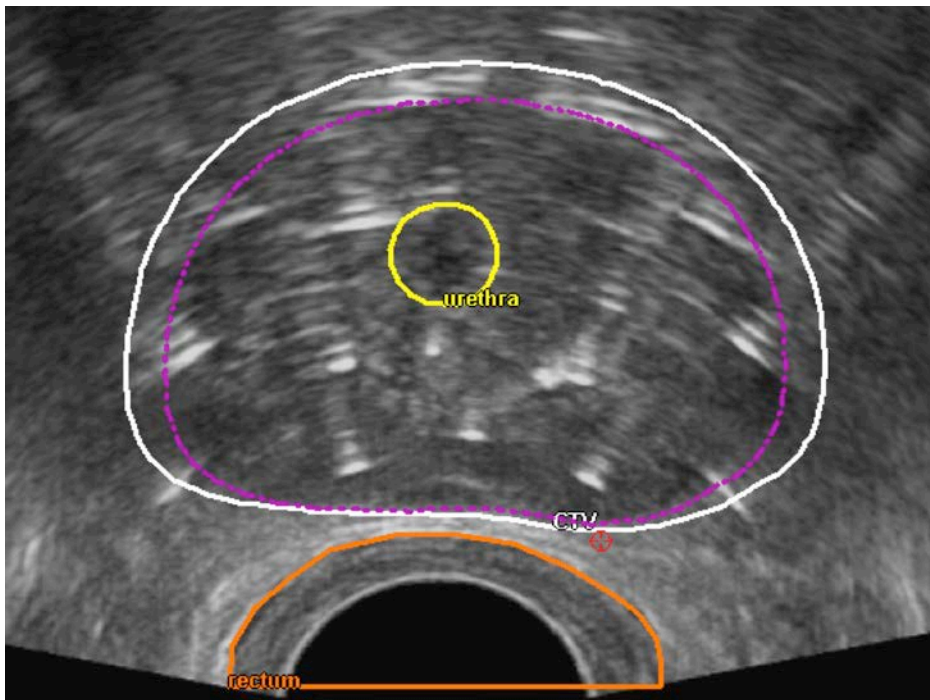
Transverse ultrasound image showing an example of a rectal contour (orange line).*
